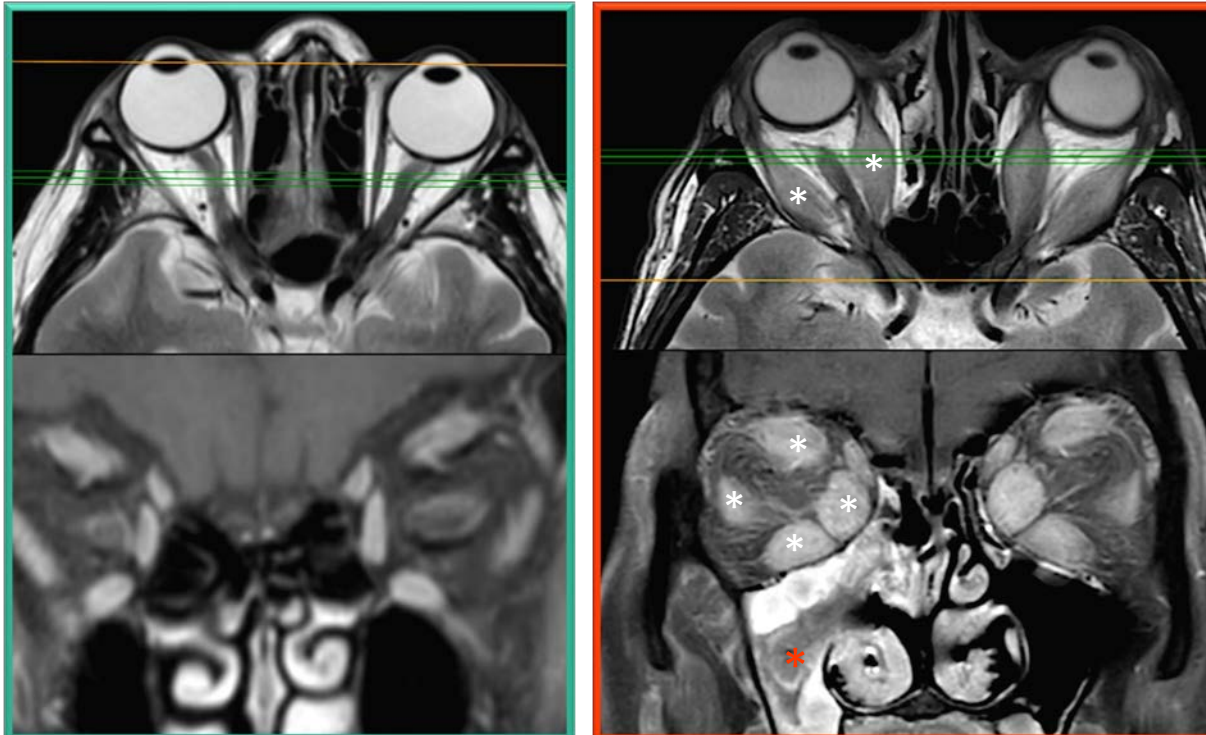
Axial T2W and coronal post-gadolinium fat saturated T1W MRI in two different patients. Normal MRI (images on the left, contoured in green). MRI findings in TAO (images on the right, contoured in red). Note exophthalmos and bilateral extra-ocular muscle enlargement (white asterisks show enlarged muscles in the right orbit). Red asterisk shows sinusitis of the right maxillary sinus.
